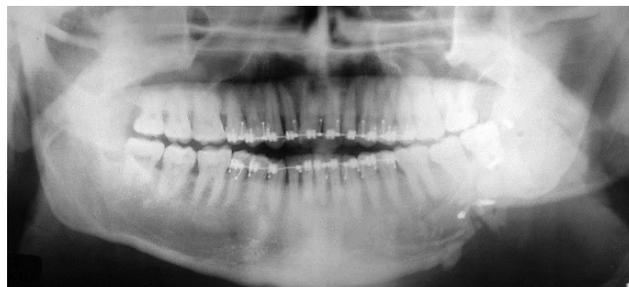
Panoramic radiograph taken 3 months after surgery
